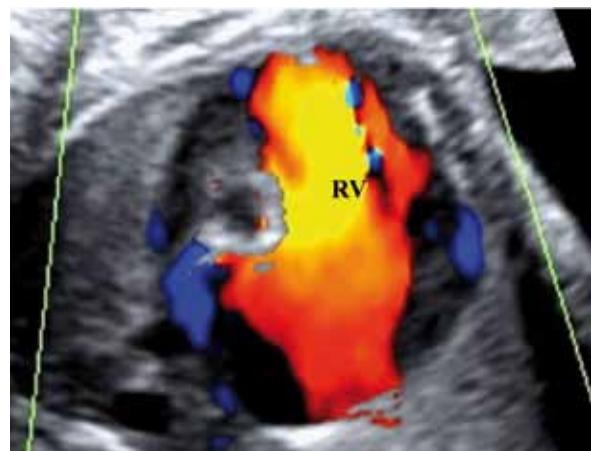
32 week of gestation. Color Doppler. Hypoplastic left heart
